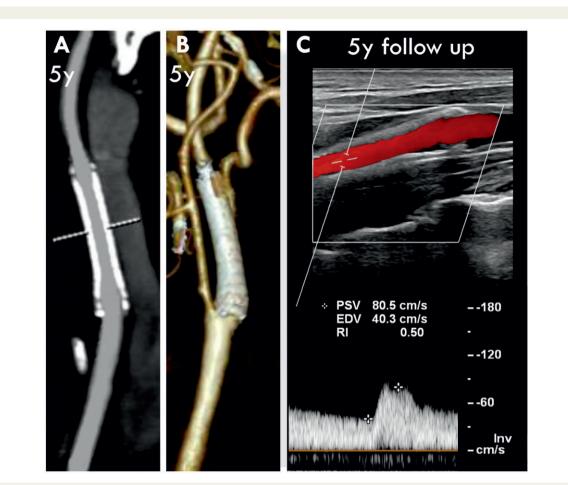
Long-term outcome, by computed tomography angiography and duplex ultrasound, of microNet-covered stent use for sealing of atherosclerosis symptomatic progression in a first-generation carotid stent. (*A*) (curved planar reformation) and (*B*) (3D reconstruction) are computed tomography angiography images 5 years after the microNet-covered stent use for symptomatic plaque progression in a first-generation carotid stent, demonstrating a re(re)-stenosis-free normal lumen and an effective long-term reconstruction of normal 3D anatomy with a fully patent external carotid artery. (*C*) Transcervical duplex Doppler demonstrating normal stent lumen with a laminar flow (top) and normal-artery in-stent velocities (bottom) at 5 years after reintervention for symptomatic (neo)atherosclerosis progression in FGS. The images are consistent with a durable reconstruction of normal anatomy that has been accompanied by an optimal clinical result.
